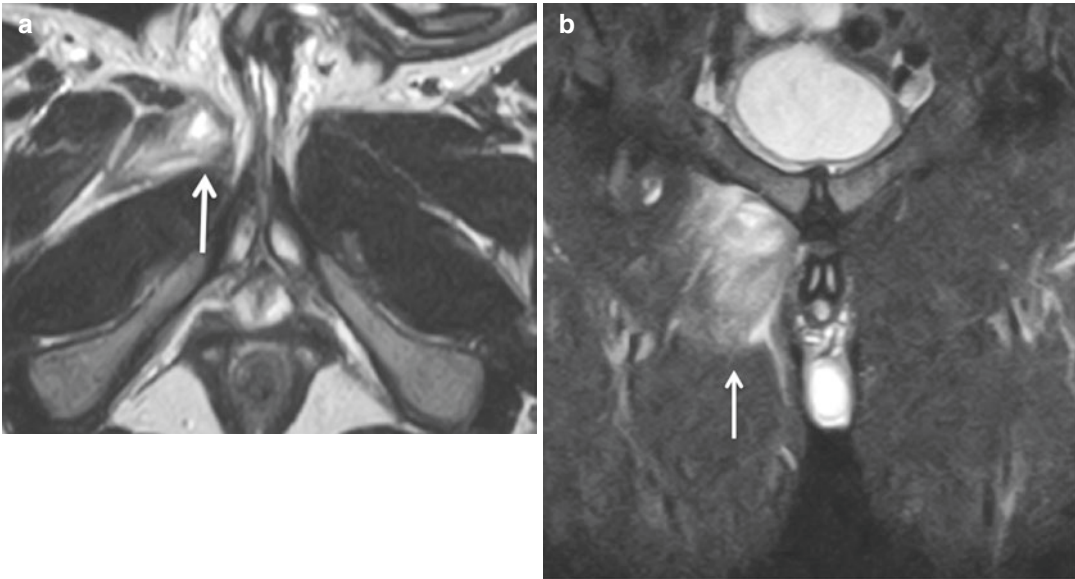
(a) MRI axial T2 and (b) MRI coronal STIR. These images demonstrate a grade 2 injury to adductor longus muscle-tendon unit, with continuity disruption of the proximal third muscle belly fibers and hematoma formation
